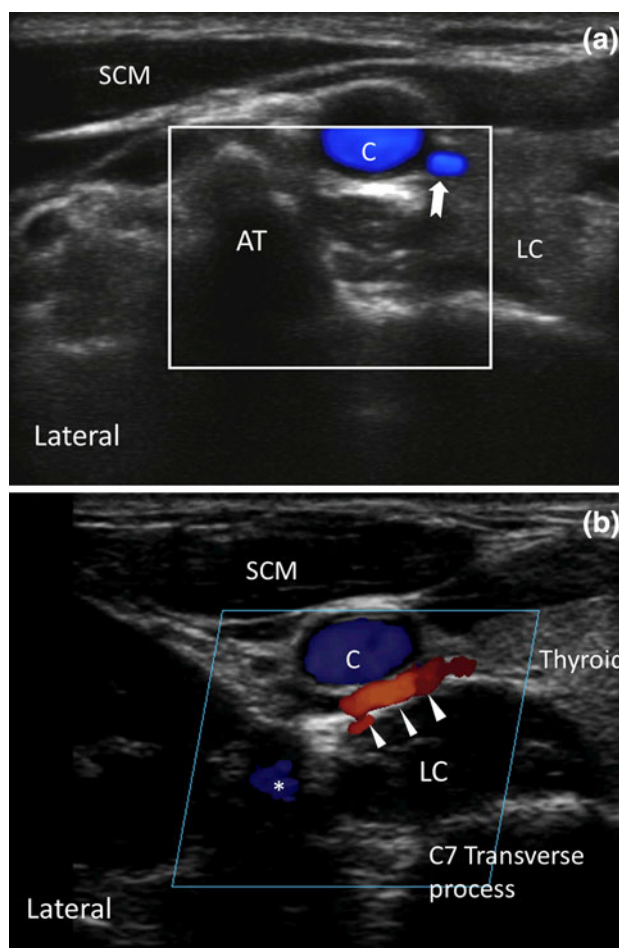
a. Ultrasound image of the neck at the C6 level on the right side showing a vessel in the short axis (bold arrow). b. Ultrasound image of the neck at the C7 level on the right side showing the inferior thyroidal artery (arrow heads) in the long axis (high-risk configuration), crossing ventral to the prevertebral fascia. AT = anterior tubercle; C = carotid artery; LC = longus colli muscle; SCM = sternocleidomastoid muscle; * = vertebral artery
